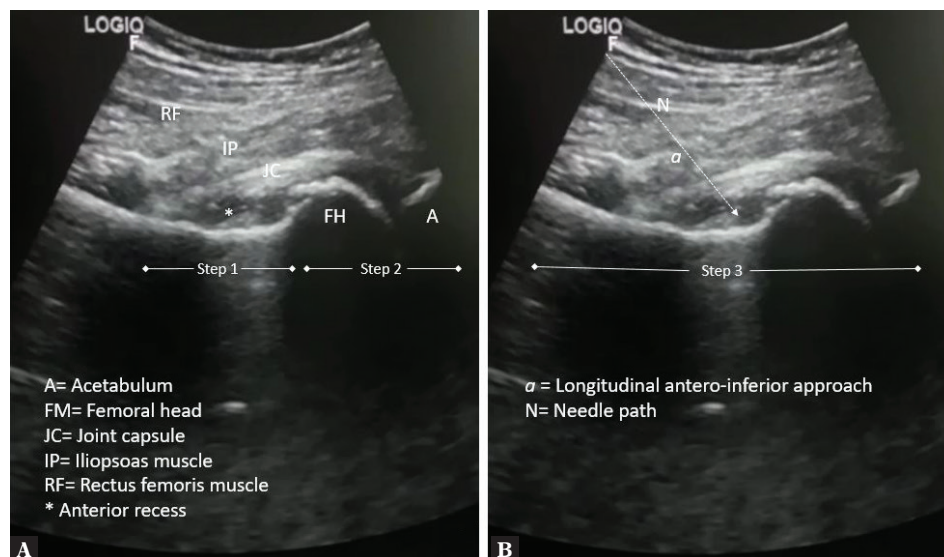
A. Ultrasound image (longitudinal oblique plane) showing the anterior recess (*) (asterisk), the joint capsule (JC), the acetabulum (A), the femoral head (FH), and B. Longitudinal antero-inferior approach (a) and needle path (N)
